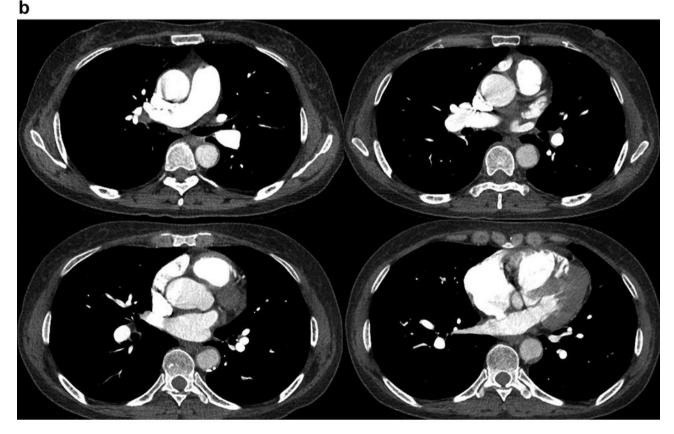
Chest CT images at the onset of progressive dyspnea. a. Mosaic ground-glass opacities and dilated peripheral artery branches (white arrow) were observed in chest CT with lung window settings; b. Contrast-enhanced CT scan of the chest in the arterial phase showed no filling defects in pulmonary arteries, while dilation of pulmonary artery trunk and right ventricular enlargement were observed.
